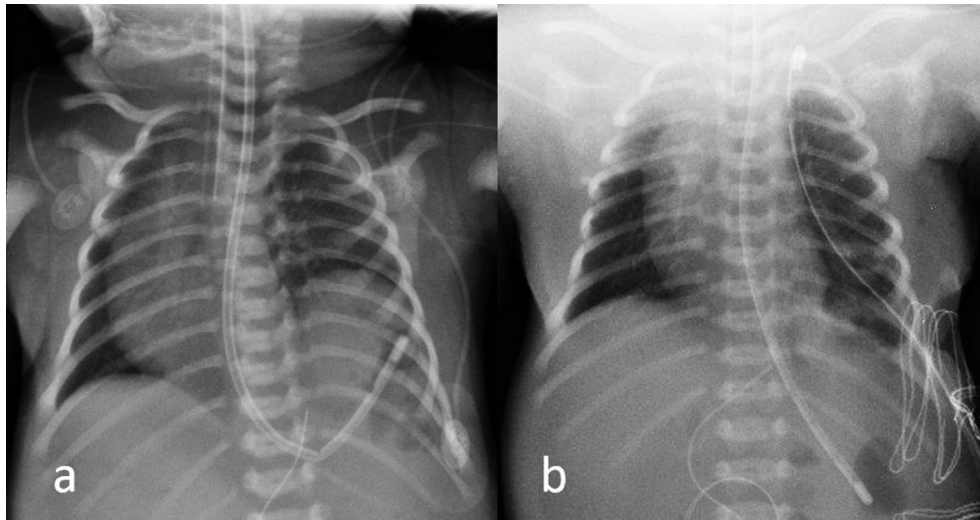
a) Chest x-ray at birth showing the left-sided CDH with shifting of mediastinum toward the contralateral side. The nasogastric tube demonstrates the intra-thoracic position of the stomach. b) Chest x-ray obtained immediately postoperatively.
